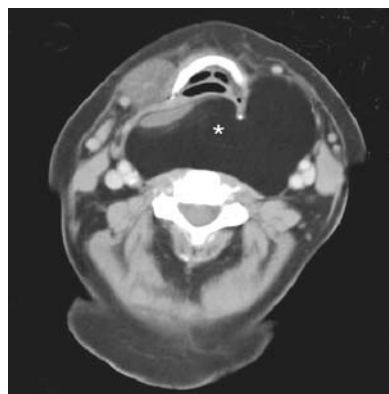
CT scan of patient with large retropharyngeal mass (*) with slight herniation into the left neck. The fatty attenuation and homogeneity of the mass is consistent with a lipoma.
